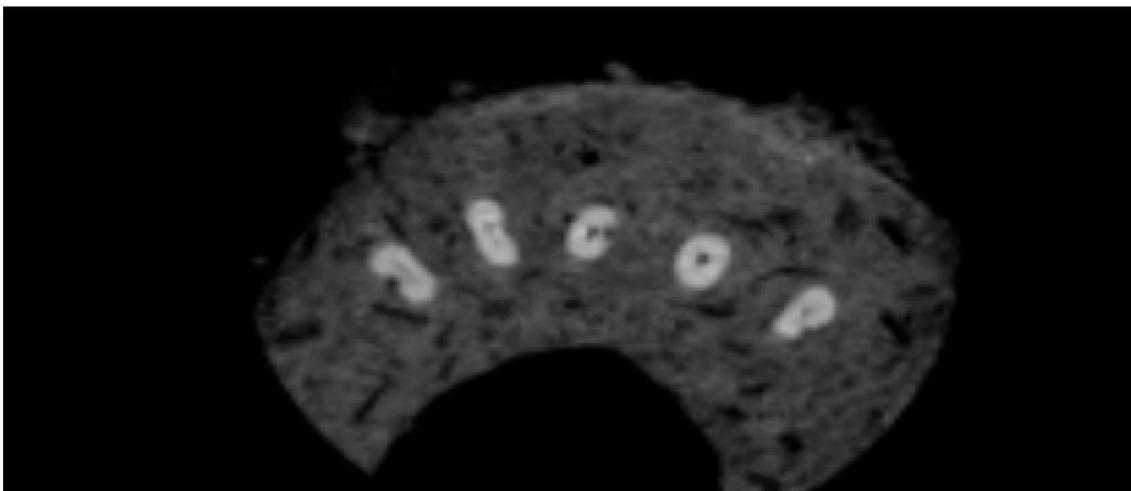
The samples were scanned in CBCT and demonstrated in axial view
